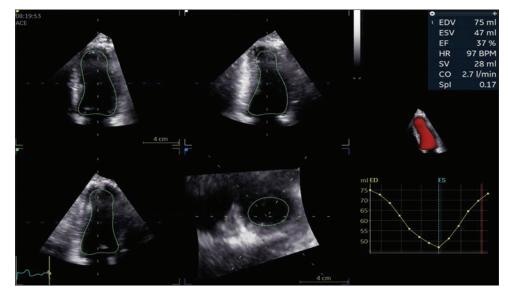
Apical 2 chamber and short-axis transthoracic ECHO views demonstrating an estimated left ventricular ejection fraction of 37%
